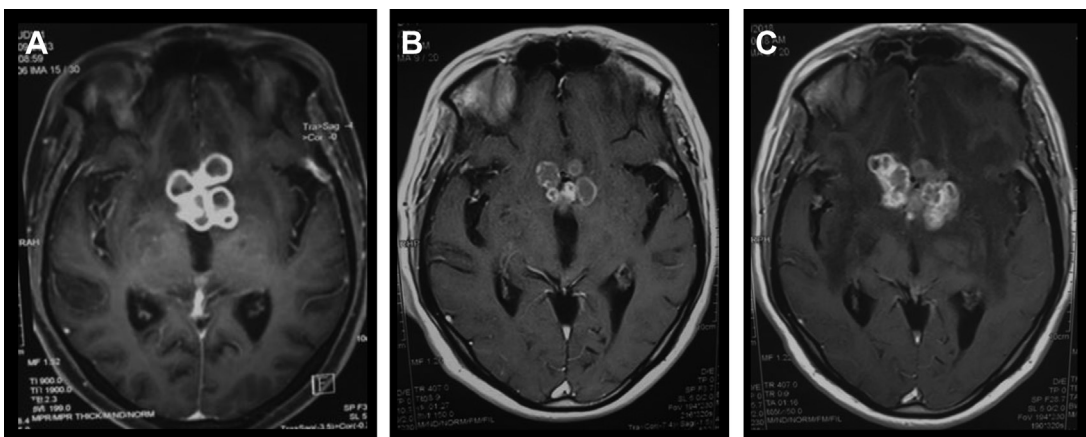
Paradoxical reaction. Axial T1-weighted postcontrast MR imaging at symptom presentation (A) shows tuberculoma formation at the basal cistern. After treatment with antitubercular therapy, for 8 months the lesion decreased in size (B), but on follow-up after a year, repeat MR imaging shows paradoxical increase in size of the lesion (C).
